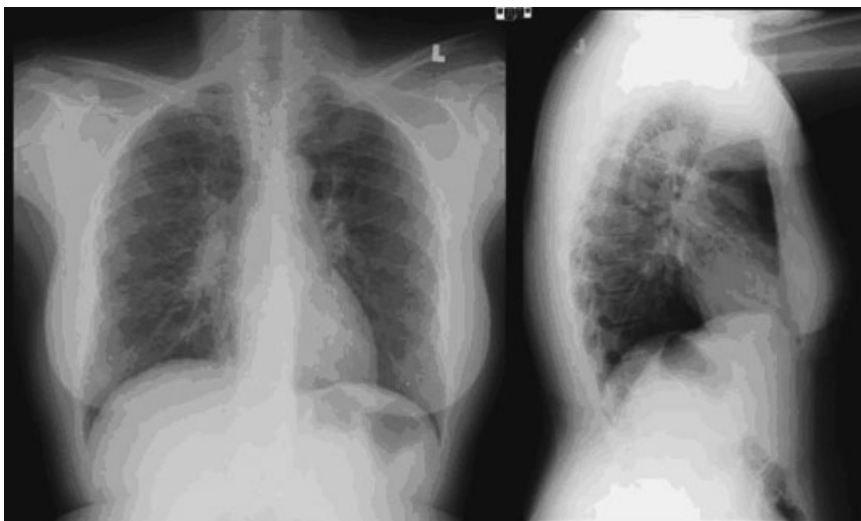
Stage II radiographic sarcoidosis. Combined hilar lymphadenopathy and upper lung zone predominant interstitial infiltrates.
